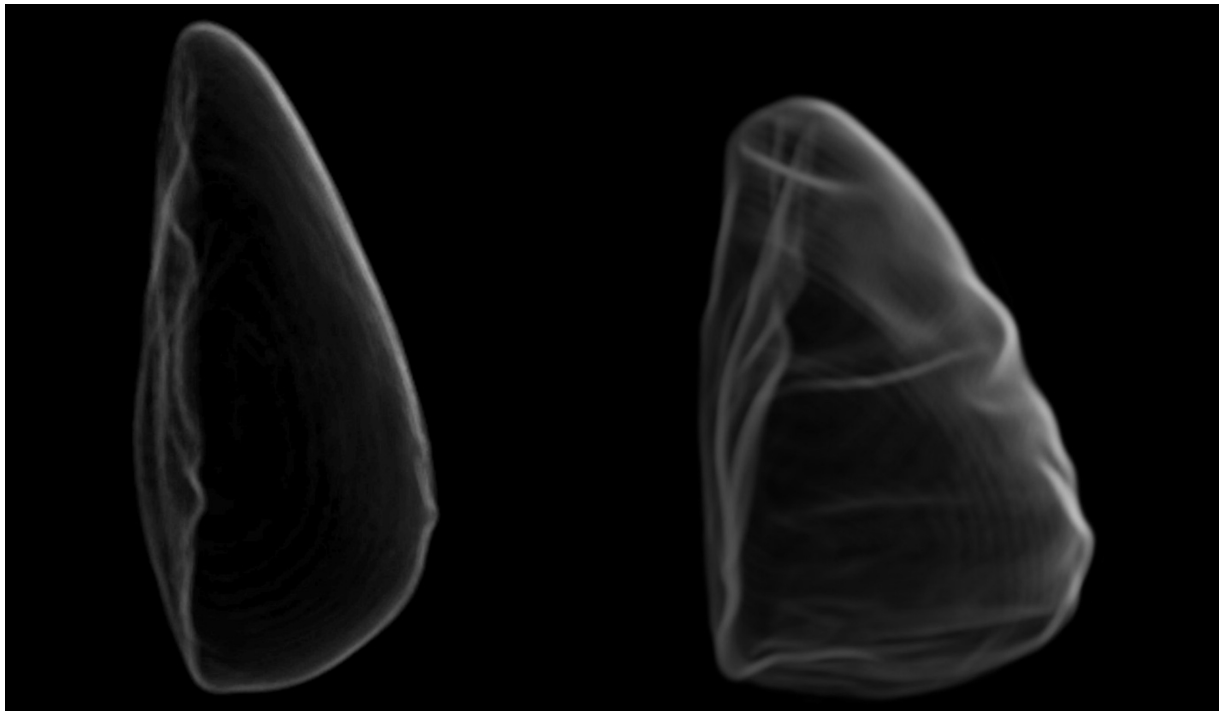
3D MRI reconstructions of the Style 410 breast implant in the supine (left) and prone (right) body position.
